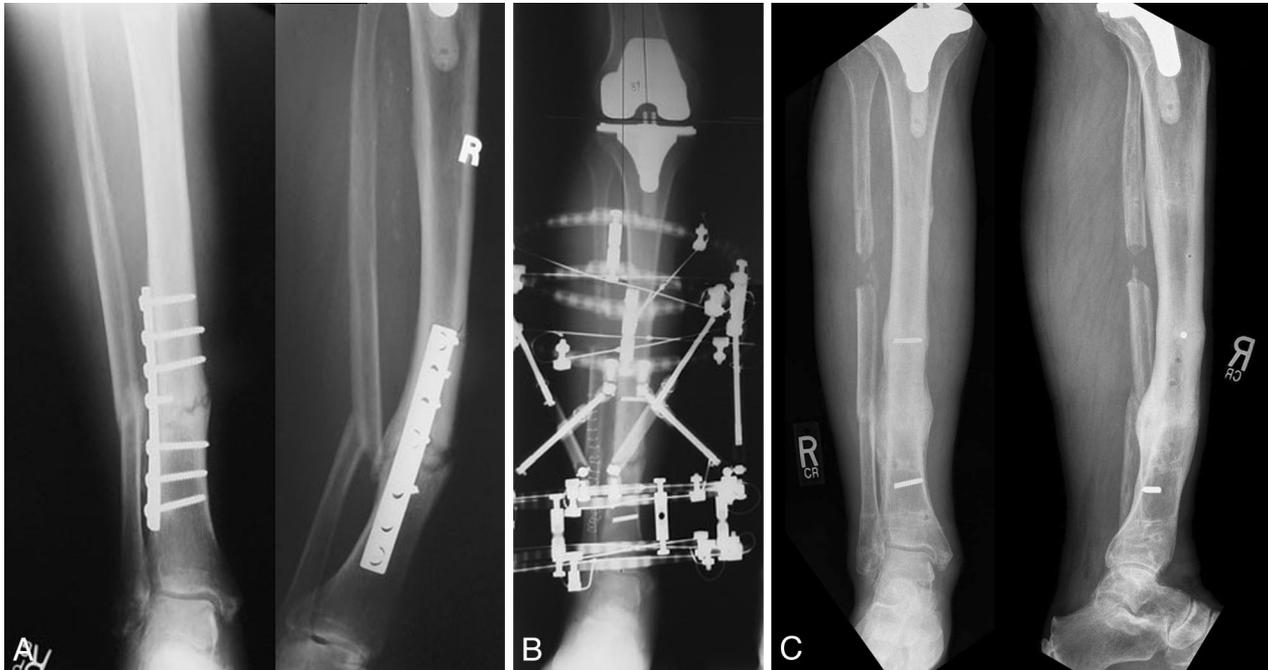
Failure of plate and screw fixation. (A) Anteroposterior and lateral radiographs of a 70-year-old man referred in with a distal tibial third nonunion below a total knee arthroplasty. The patient had a past medical history of multiple medical problems, including diabetes mellitus. The patient had had three prior failed attempts at internal fixation and bone grafting. In this case, the failure of internal fixation treatment should be thought of as biologic failure as the bone failed to unite but the hardware had remained intact for several months at the time of presentation. (B) Anteroposterior radiograph during Ilizarov treatment of the nonunion with concomitant deformity correction. Because this patient required removal of the plate and screw fixation, the patient was treated with local bone grafting at the time of hardware removal. To facilitate deformity correction, the patient was also treated with partial excision of the fibula. (C) Anteroposterior and lateral radiograph of the tibia following removal of the Ilizarov external fixator. Note the solid bony union at the nonunion site with correction of the patient's deformity.
